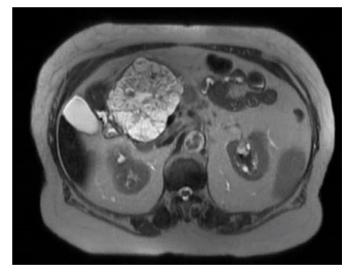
Magnetic resonance imaging (T1-weighted image on the left; T2-weighted image on the right) showing a cluster of small cysts and a central stellate scar in the head of the pancreas.
